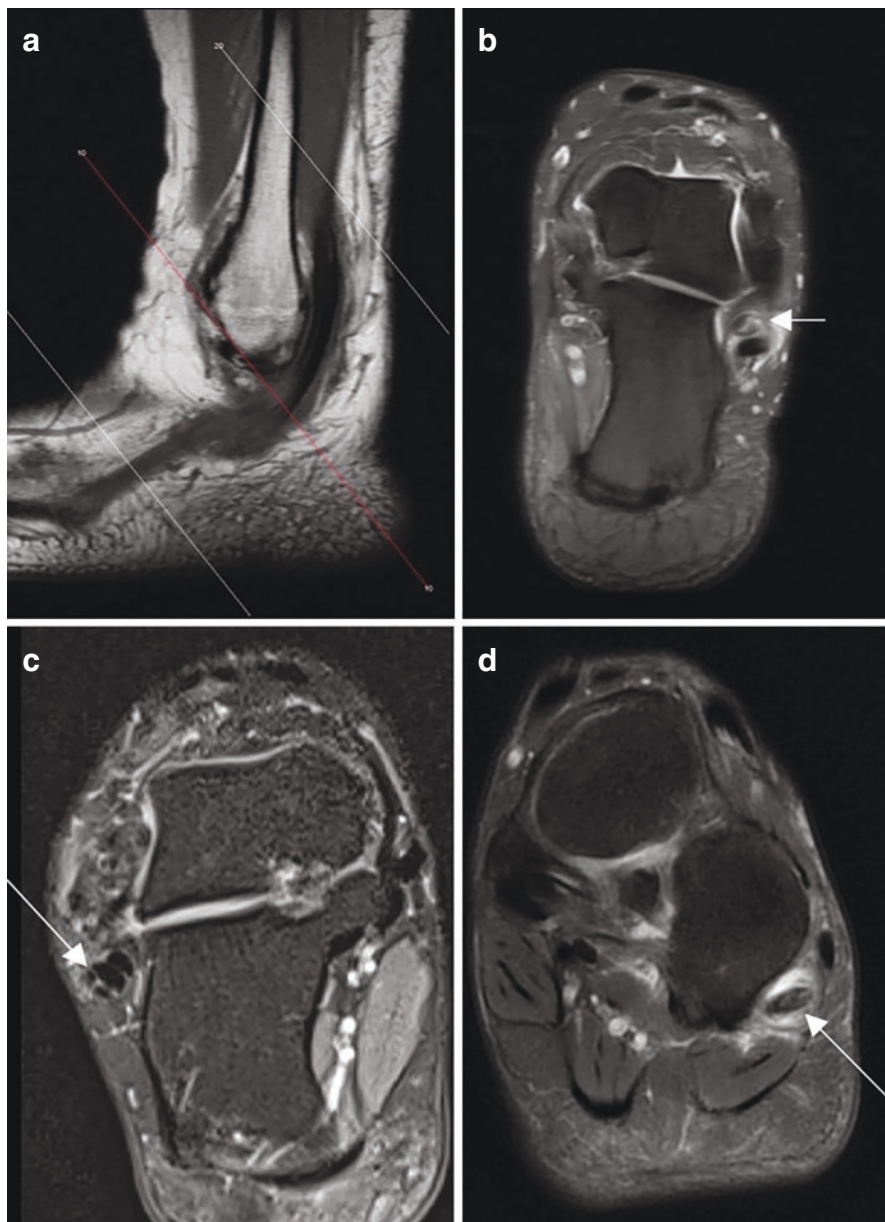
Peroneal tendon tears on MRI. (a) Sagittal reconstruction showing orientation of para-axial reconstructions. (b) Para-axial reconstruction showing peroneus brevis tear at the level of the retromalleolar groove. (c) Peroneal oblique reconstruction showing peroneus longus split tear near the level of the peroneal tubercle. (d) Coronal reconstruction showing peroneus longus tear within the cuboid groove. (Used with permission from James W. Brodsky, M.D. Baylor University Medical Center, Dallas, USA)
